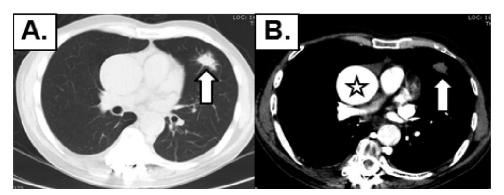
Incidentally detected bronchogenic carcinoma and ascending thoracic aortic aneurysm in 68-year-old man. Axial plane lung window (A) and soft tissue window CT (B) showed spiculated mass measuring 3.3 cm in diameter at lingular segment of left upper lobe (arrow) and ascending thoracic aortic aneurysm (star). The mass was pathologically proved to be adenocarcinoma.
